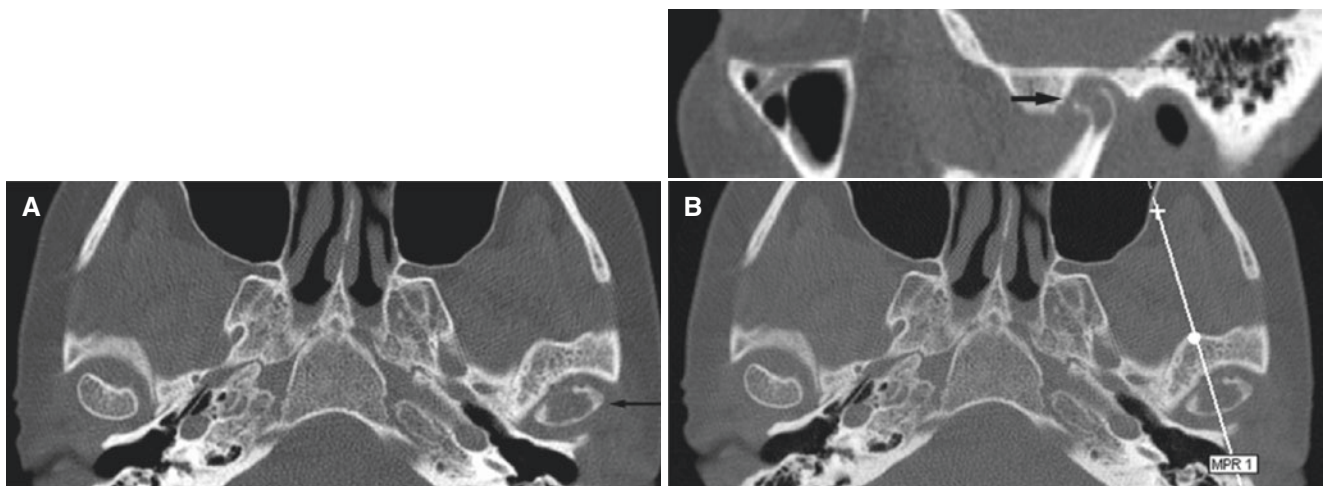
Inflammatory arthritis; patient without known generalized joint disease. (A) Axial CT image shows severe destruction in mandibular condyle (*arrow*). (B) Oblique sagittal CT image and axial CT image (with *cursor line*) show destruction of the entire condyle (*arrow*). (C) Oblique sagittal T1-weighted pre-Gd and (D) oblique sagittal T1-weighted post-Gd MRI show contrast enhancement, particularly in the upper compartment and in the condyle (*arrow*), and thin, elongated disc, apparently in normal position. (E) Oblique sagittal (post-Gd) open-mouth MRI shows increased signal from condyle marrow (*arrow*)
